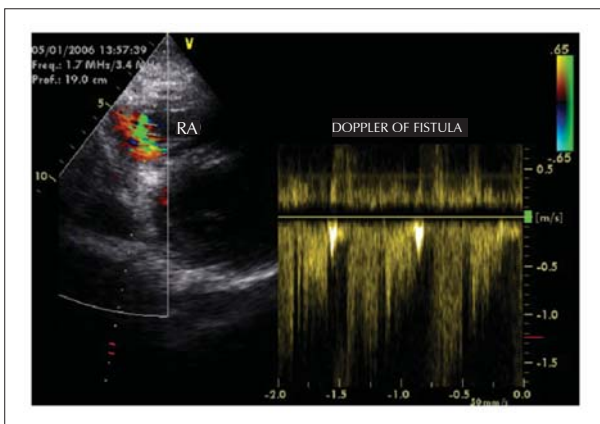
Doppler showing continuous flow to the right atrium (RA).
